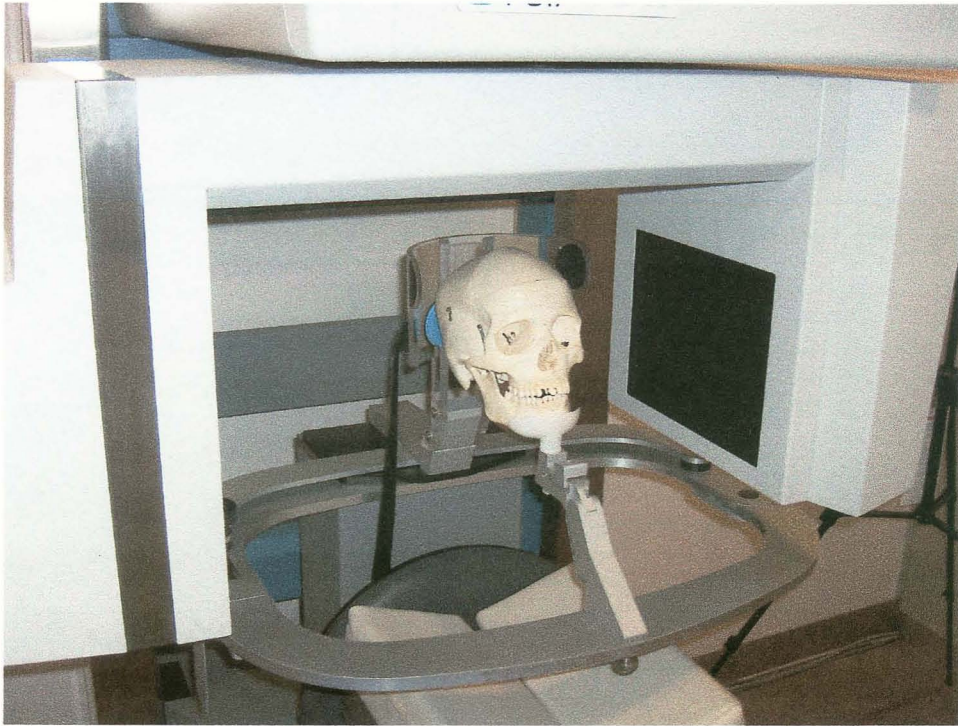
Skull positioning for cone beam computed tomography scan
